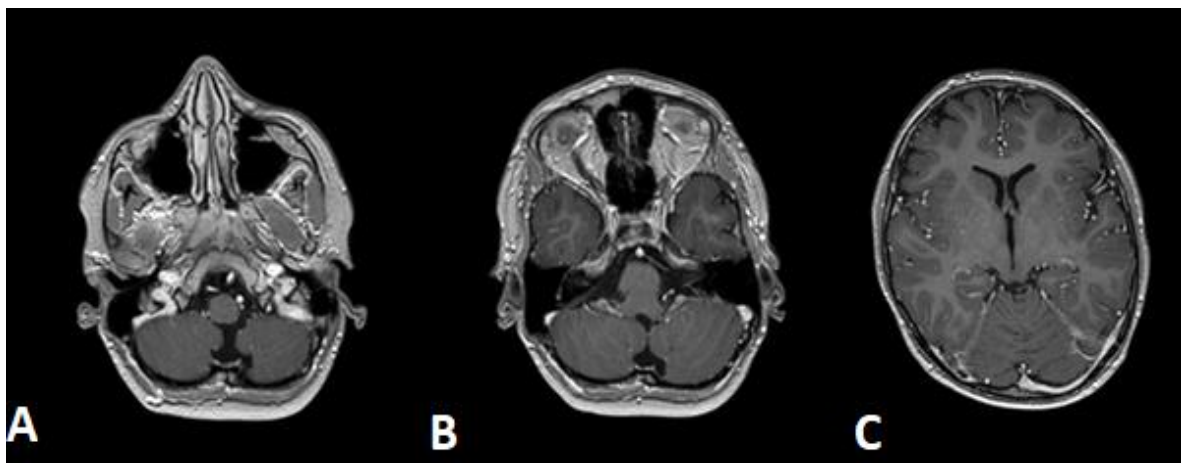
Resolution of sinuses thrombus upon follow up MRI scan in the left internal jugular (A), sigmoid (B), and transverse (C) dural venous sinuses.
